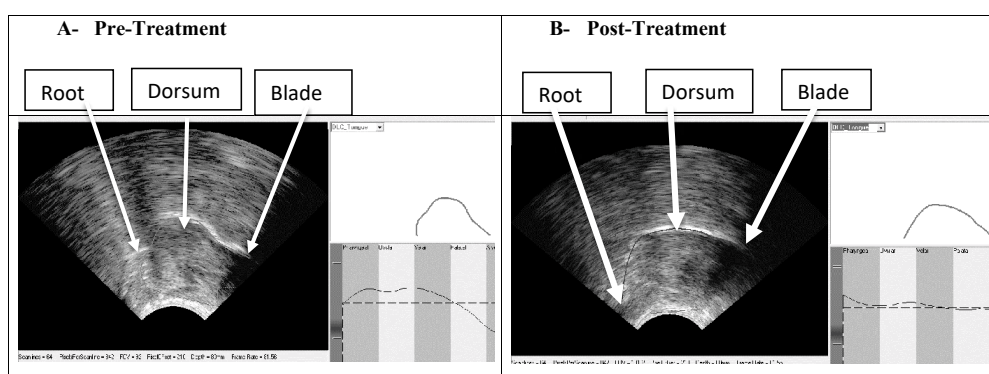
The Visual Display of Ultrasound Data from the Articulate Assistance Advanced (AAA) Software During the Production of /s/ in the Word /sevin/. 3A: Data Captured Pre-treatment, 3B: Data Captured Post-treatment
